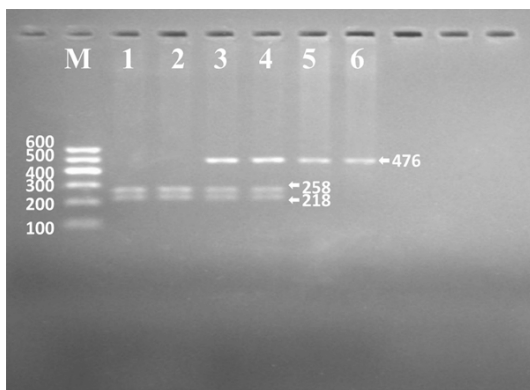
Electrophoresis of genotyping of the *PLA2G6* rs2760114 mutation. Lane M, 100-bp marker ladder; lanes 1 and 2, TT genotype (258- and 218-bp); lanes 3 and 4, CT genotype (476-, 258- and 218-bp); and lanes 5 and 6, CC genotype (476-bp).
